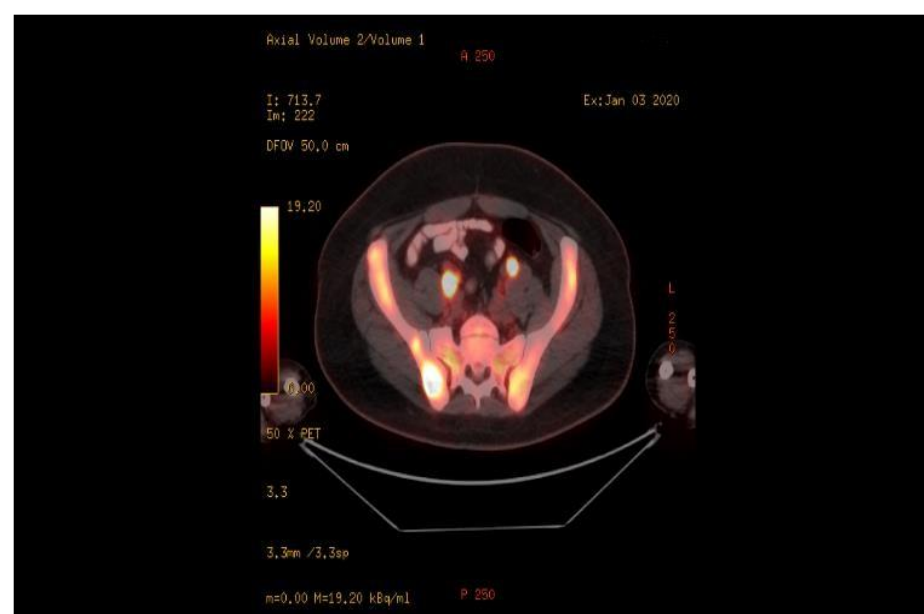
Involvement areas of lymphoma in the iliac bone and sacroiliac joint in PET-CT of the first case taken two months after the diagnosis of axial spondyloarthritis.
